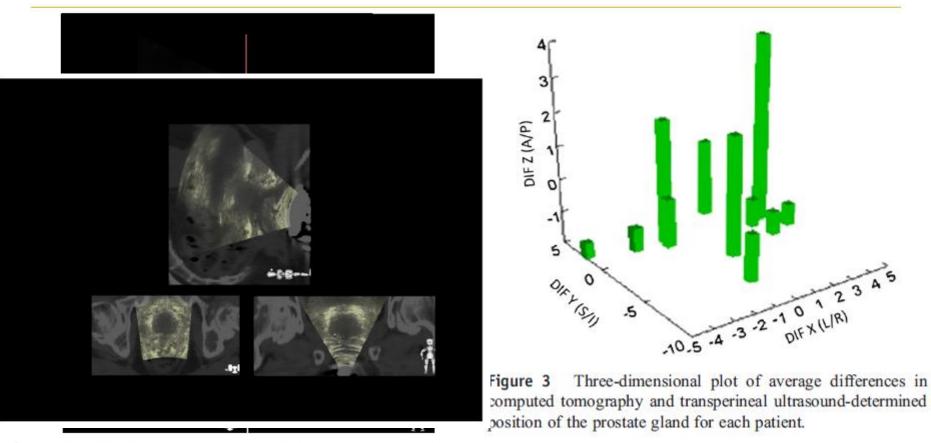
Sagittal (top), axial (bottom left), and coronal (bottom right) transperineal ultrasound images of the prostate.
